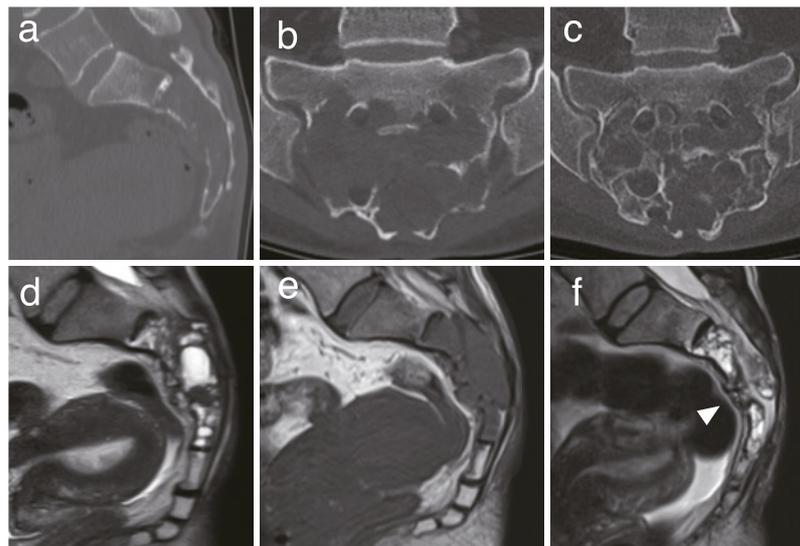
Image of the giant cell tumor of bone in the sacrum. Reconstructed sagittal (a) and coronal (b) computed tomography views revealing a large lytic lesion extending from S1 to S5. Magnetic resonance images (d and e) showing that the tumor extends to the sacrum's ventral and dorsal sides. After administering denosumab, ossification of the osteolytic lesion was clarified (c) and the tumor size decreased (f), including extraosseous tumors (white arrowhead).
